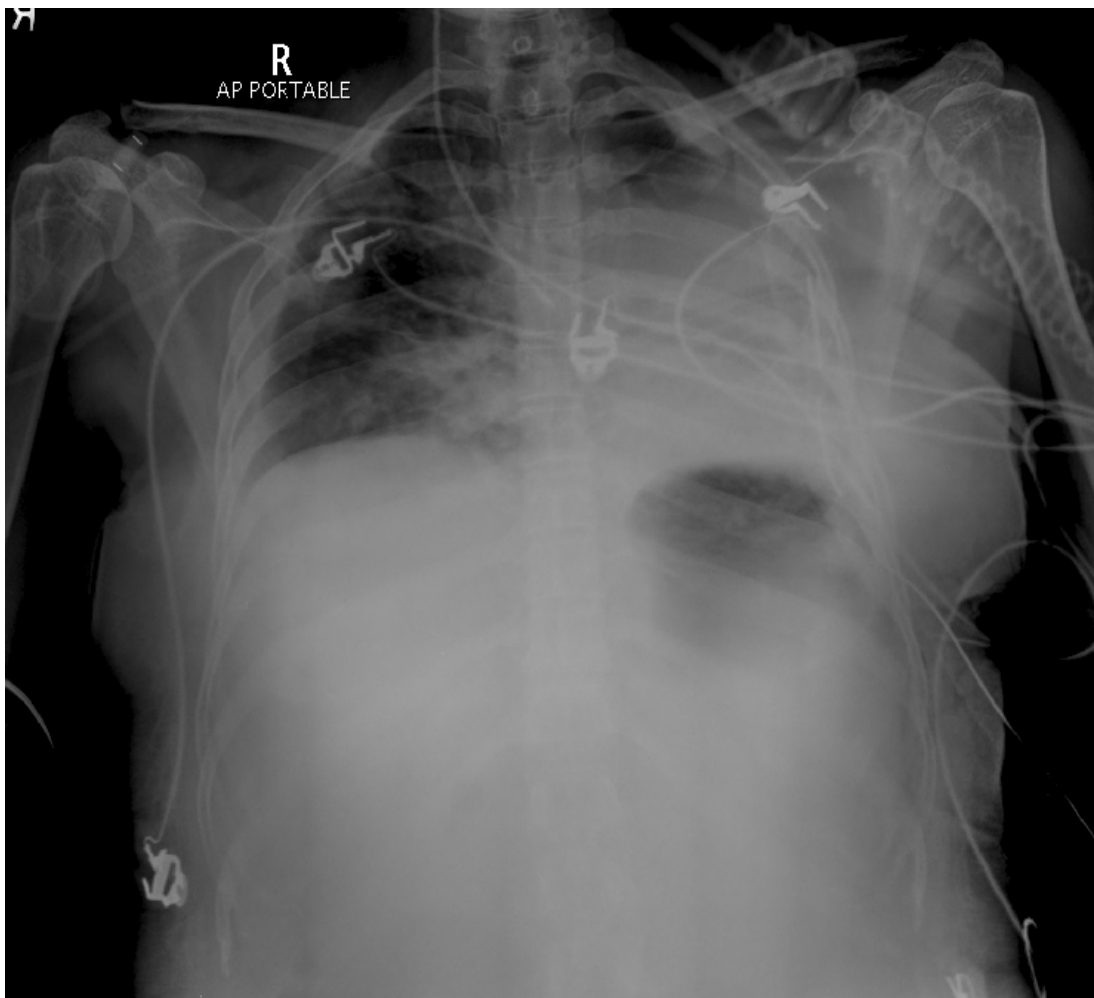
X-Ray Chest showing left Cardiac Herniation
